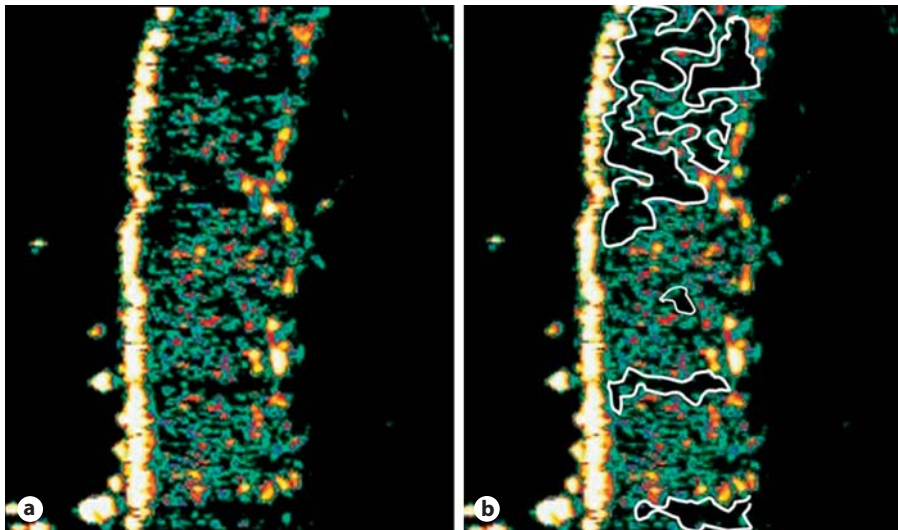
Postflight skin physiological measurements: ultrasound images, R +31 days.
